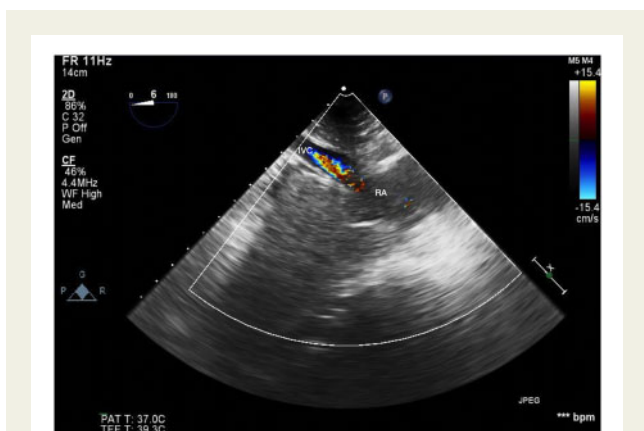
Case 2: Transoesophageal echocardiogram demonstrating flow acceleration across the inferior vena cava-right atrial anastomosis.
